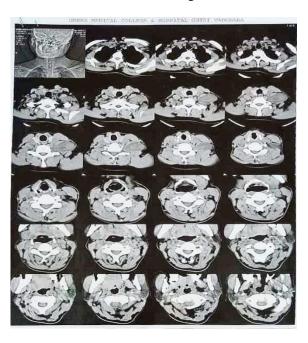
CT Scan slices from level of clavicle to base of skull.
